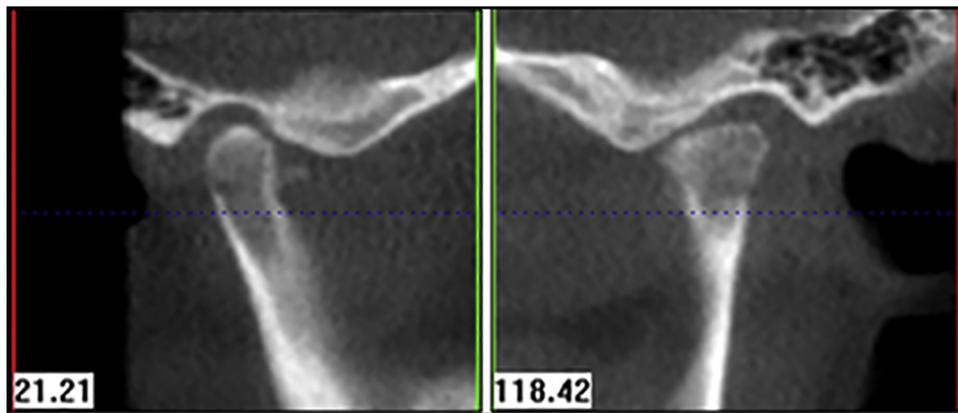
CBCT 2 months after disc repositioning. Note the decreased articular disc space bilaterally.
